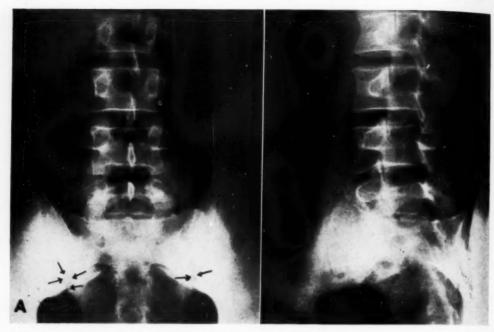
A. Partial ankylosis of the sacroiliac joints. Mottled rarefaction (arrows) and osteosclerosis are still prominent. B. Oblique view, showing partial ankylosis of the lower portion of the left sacroiliac joint. The lumbar spine was involved clinically; yet the apophyseal joints appear roentgenographically normal. Sacroiliac joint changes are usually advanced long before the apophyseal joints show changes.
